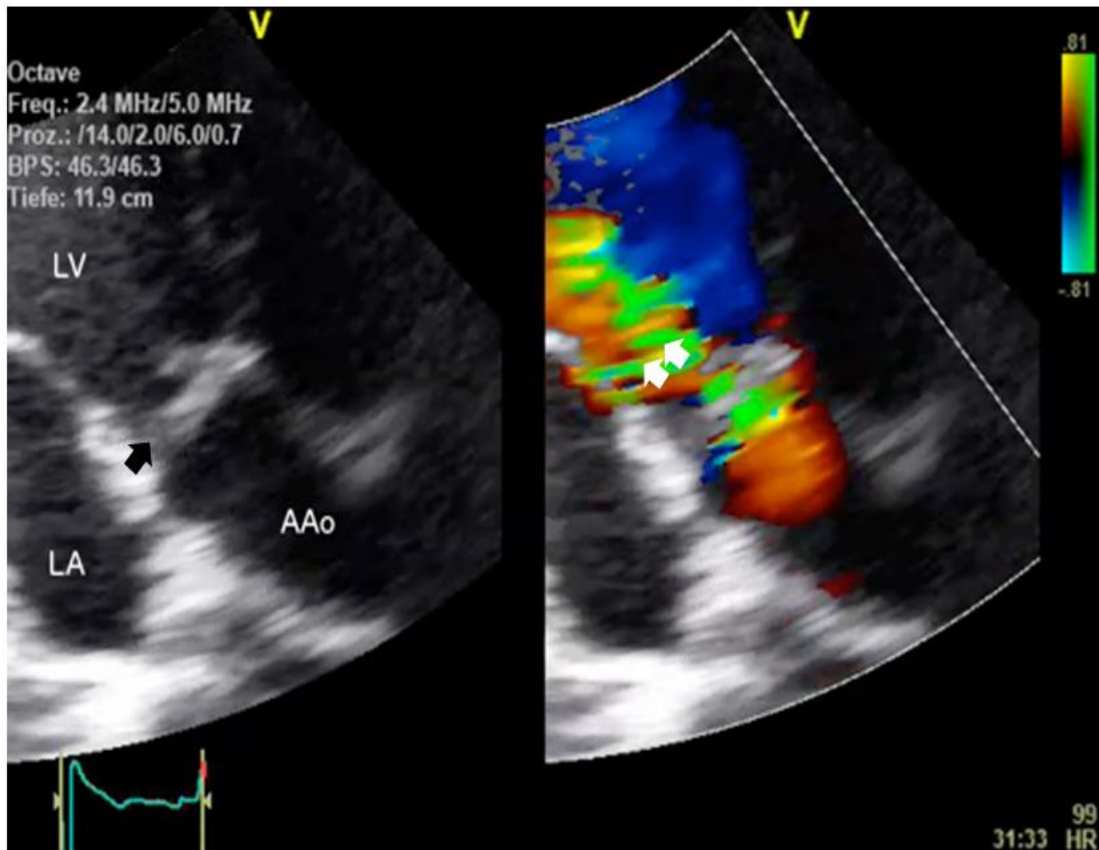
High-grade aortic regurgitation in transthoracic echocardiography
